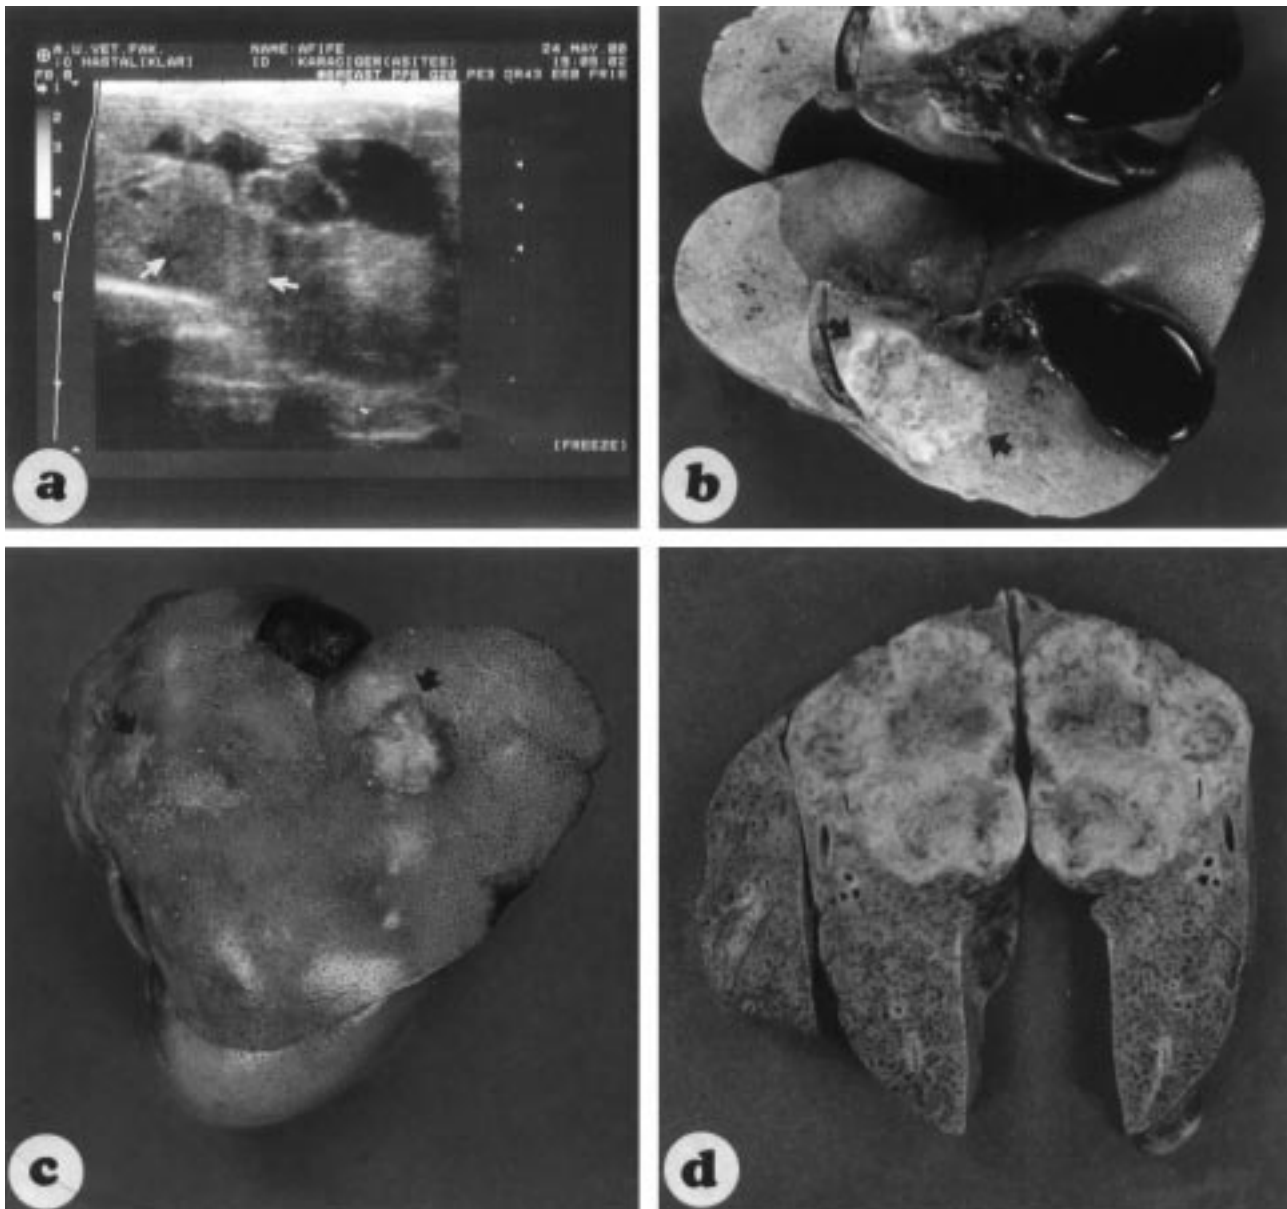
The ultrasonographic and gross appearances of the liver concerned. (a) ultrasonogram of the liver shows remarkable dilatation of the cystic and hepatic biliary ducts and gall bladder and a hypoechoic mass (arrows). Note the mass compressed immediately adjoining the biliary duct. (b) The cut surface of the liver as a sectioned approximately adjoining plane with the ultrasonogram of Figure 1a. Note ill-defined tumorous mass (arrows) and dilatation of the cystic and hepatic biliary ducts and gall bladder by this tumorous mass. (c) The surface of the liver including foci similar to scar tissue (arrows). (d) The cut surface involved by extensive tumorous foci.
